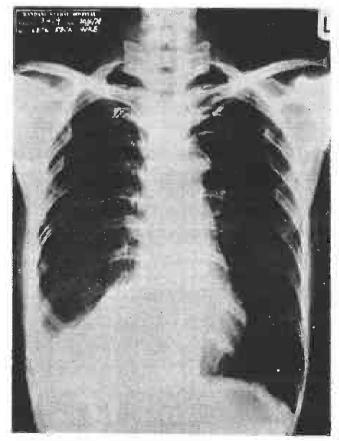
& 4 Chest radiographs of the same patient with resolving right pleural effusion on the 4th and 7th post-operative day respectively.
